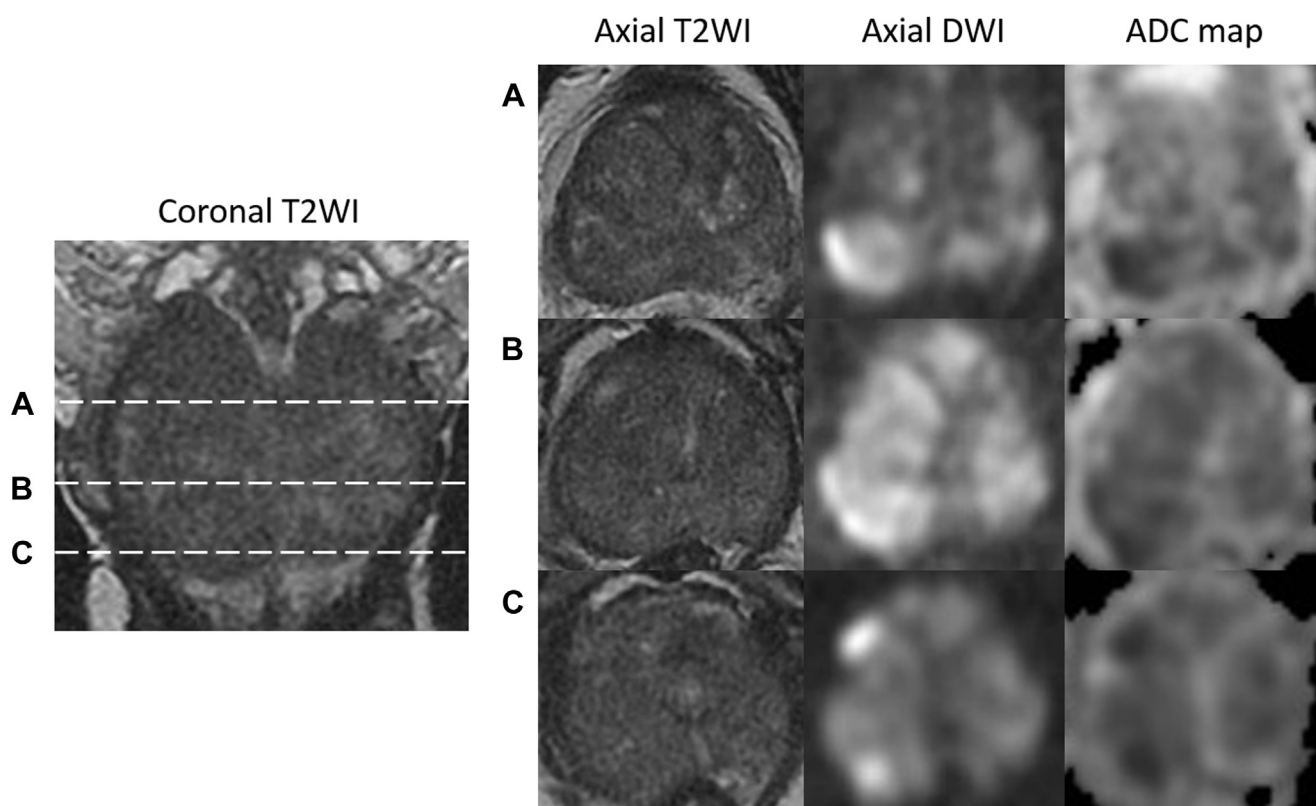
Coronal T2WI and corresponding axial T2WI DWI (b-value 1,400) and ADC maps at the levels of the prostatic base (A), midgland (B), and apex (C), demonstrating diffuse low T2 SI in the PZ and TZ and multifocal areas of high SI on the DWI and low SI on the ADC maps. This results in a PI-RADS v2 score of 5 for both T2WI and DWI [1].
